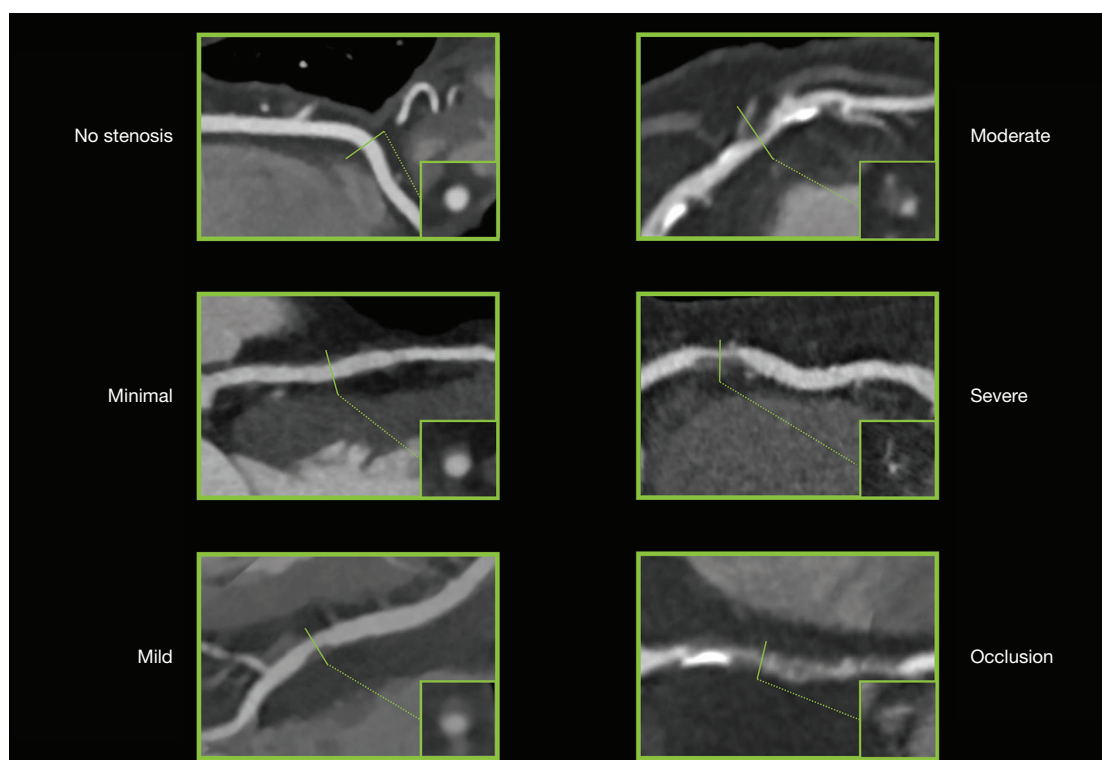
Representative images of stenosis categories using coronary CT angiography (CTA).
